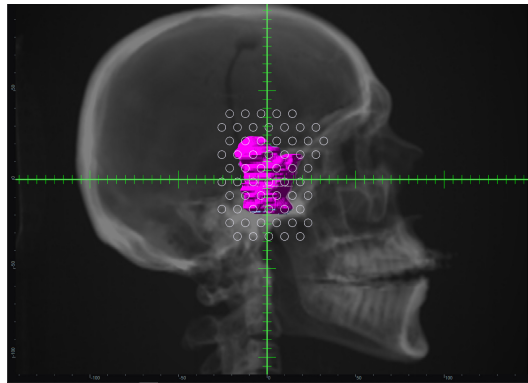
Proton pencil-beam spot placements for a single energy layer. The tumor is shown in pink, and the anatomy is shown as a two-dimensional projection of the treatment planning CT scan.
